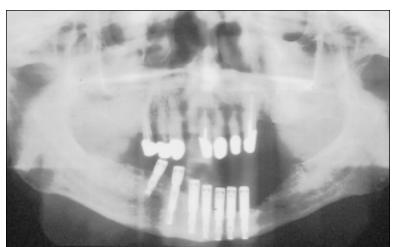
Panoramic radiograph after abutment connection (patient 13).
